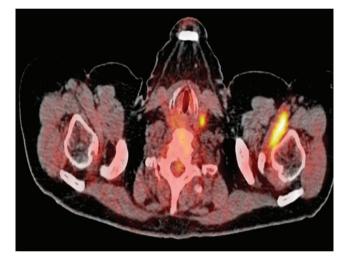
¹⁸F-FDG PET/CT revealed hypermetabolic uptakes in cervical lymph nodes and lungs in 6 patients
